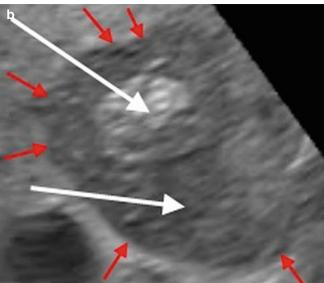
Liver metastases. (a, b) The ultrasound characteristics of a lesion may be influenced by the degree of necrosis in response to chemotherapy. (a) This post-chemotherapy-treated colorectal liver metastasis is a heterogeneous lesion, which is predominantly hypoechoic with a central hyperechoic zone. The hyperechoic zone may represent calcification. (b) The border of the lesion is irregular as showed by *red*
